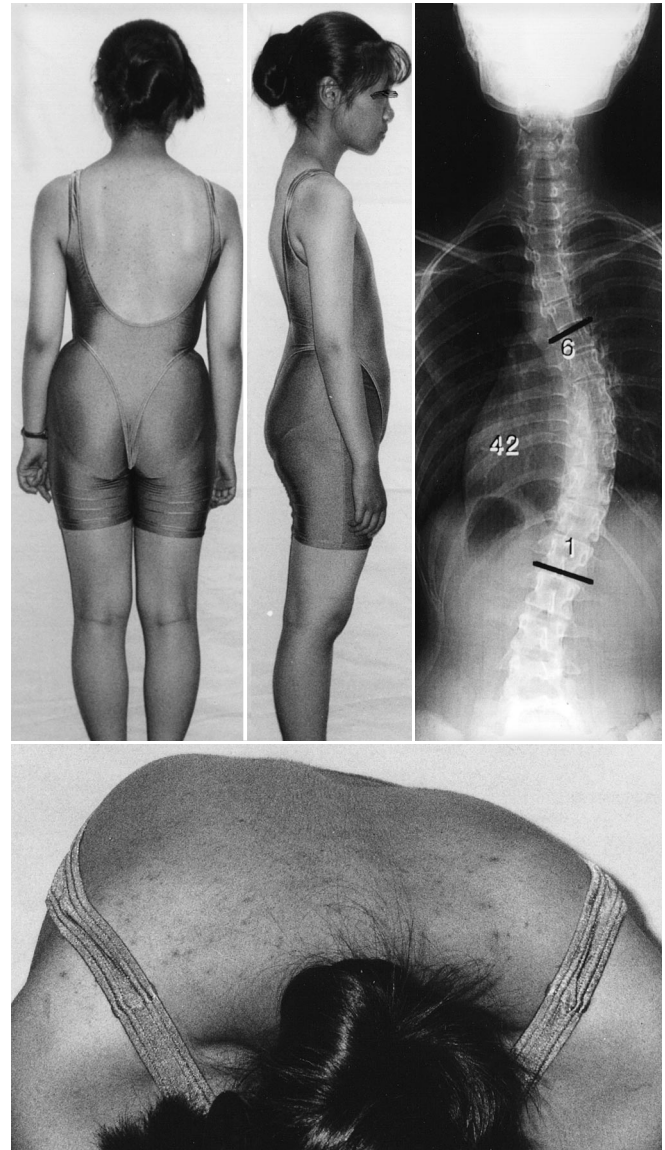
Photographs and radiograph of a 15-year-old girl (case 2)
